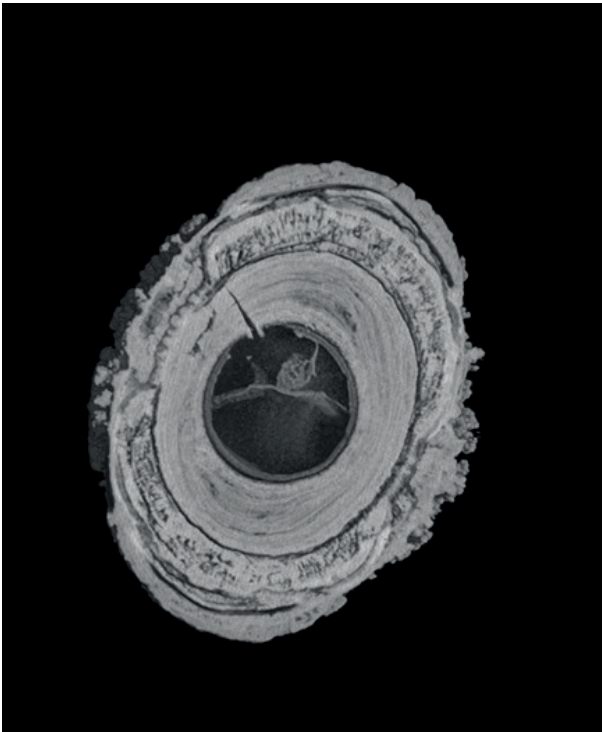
Micro CT scan of a sialolith, showing an organic nucleus surrounded by laminated layers of organic and inorganic substances (courtesy of professor Johan Aps, University of Washington, School of Dentistry)
